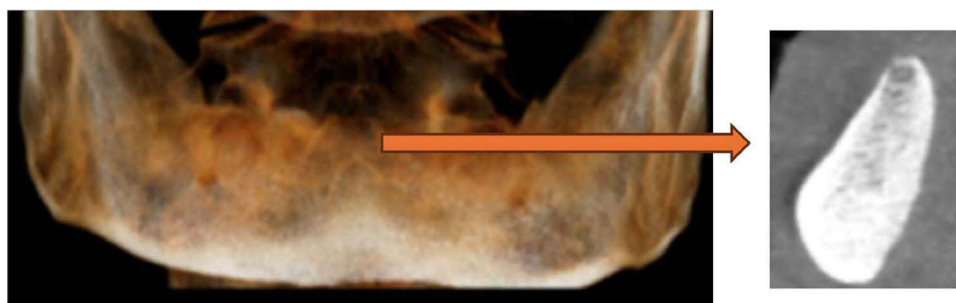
3D CBCT image of the mandible showing areas of vertical bone resorption, particularly along the alveolar ridges.
